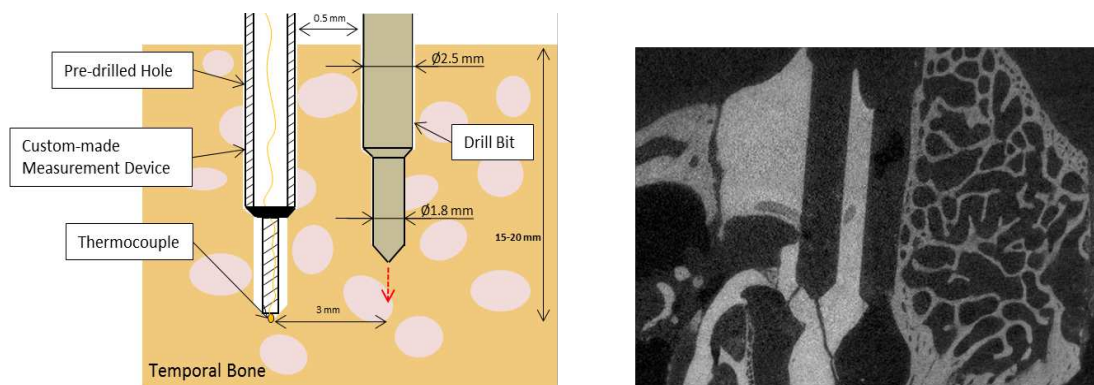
Left: Measurement setup with thermocouple and drill bit advancing into the bone; Right: Post-op  $\mu$ CT of two neighboring drilled holes.
